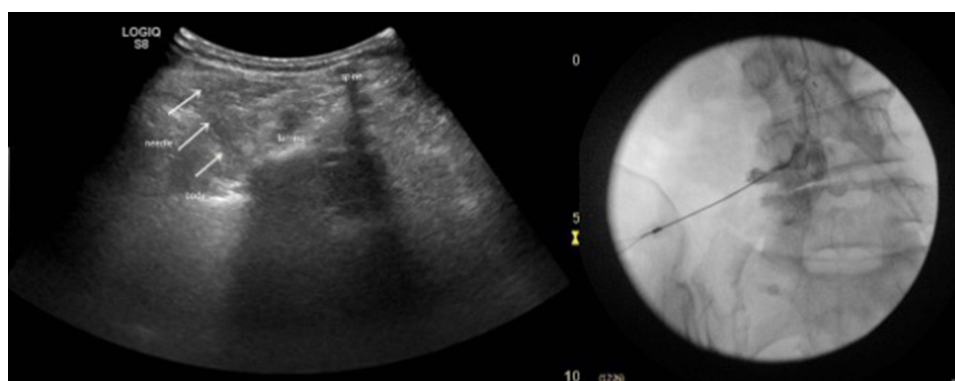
Ultrasound guided transforaminal injection at L4. Needle, needle tip, and dorsal surface of vertebral body are demonstrated. Fluoroscopic confirmation with contrast shows epidural spread indicating appropriate needle tip position.
